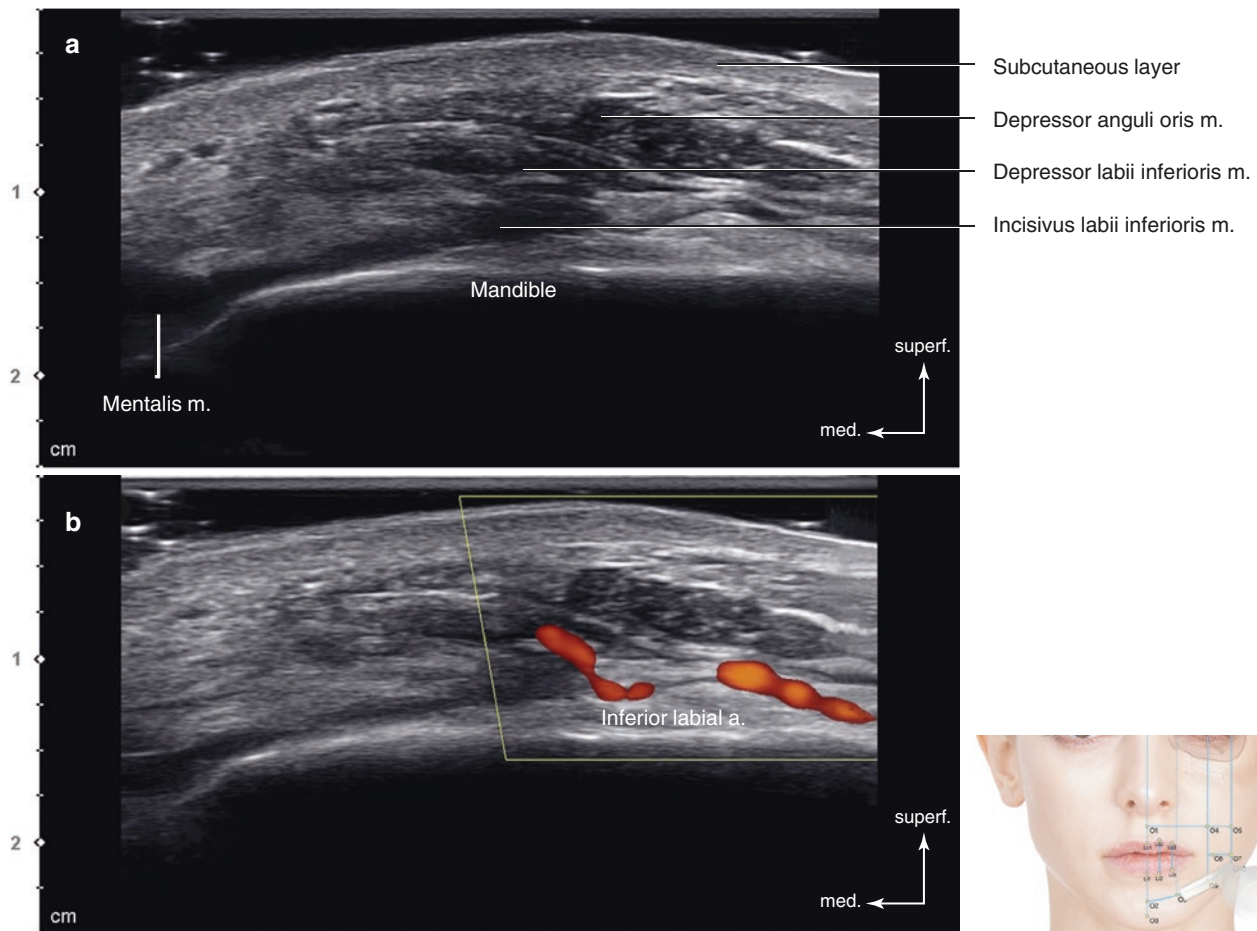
Ultrasonography of the intersection point of TL8 and PL2 (O9). (a) B mode (transverse view, 15 MHz by linear transducer) and (b) Doppler mode (transverse view, 15 MHz by linear transducer). (Published with kind permission of © Hee-Jin Kim 2020. All Rights Reserved)
